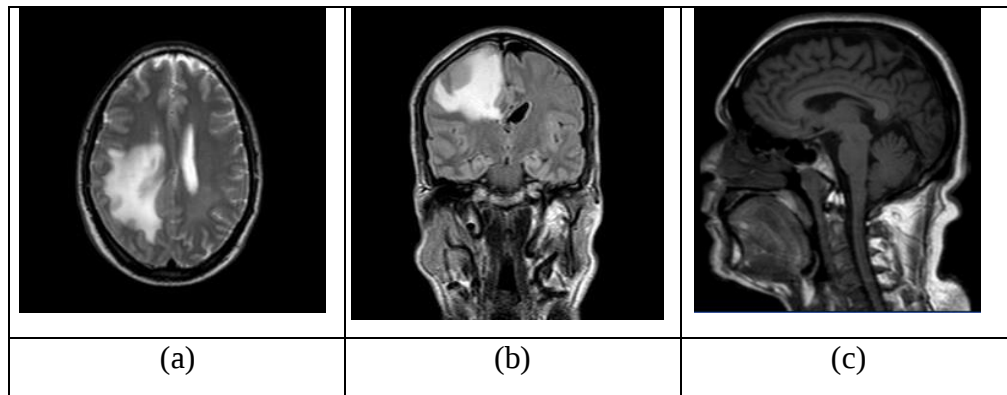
MRI orientations (a) Axial (b) Coronal (c) Sagittal
